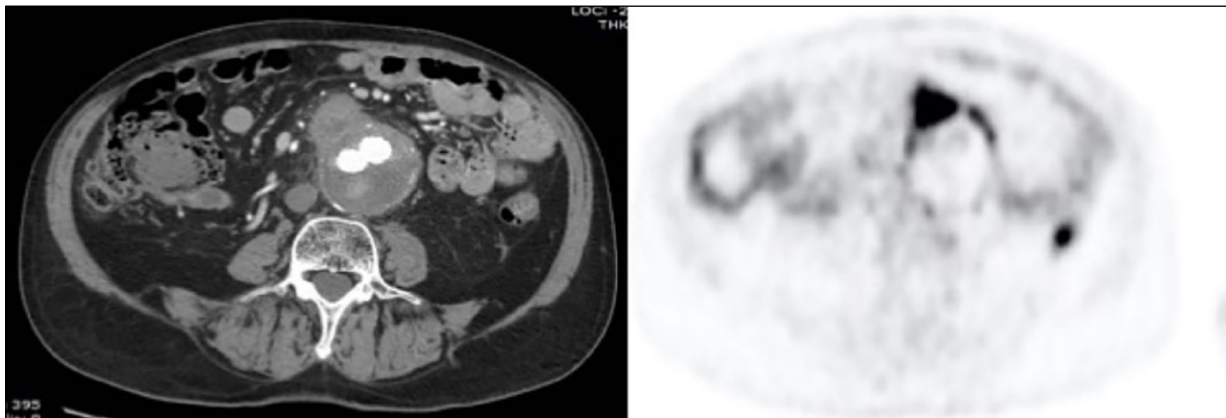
Transaxial images of the contrast enhanced CT (left panel) and $[^{18}\text{F}]$ FDG PET/CT (right panel) showing the bulging at the right antero-lateral side of the aortic wall uptake corresponding to an intense area of $[^{18}\text{F}]$ FDG uptake of focal pattern extending to the anterolateral vascular wall where the uptake presented a linear pattern native abdominal aorta.
